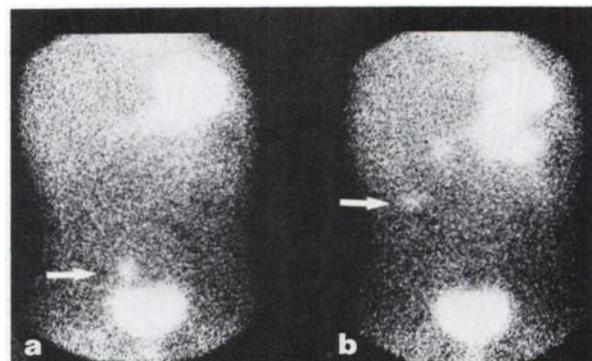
Positive scintigrams showing a Meckel's diverticulum (arrow) that changes position in the abdomen, (a) at 30 min; (b) at 45 min.
